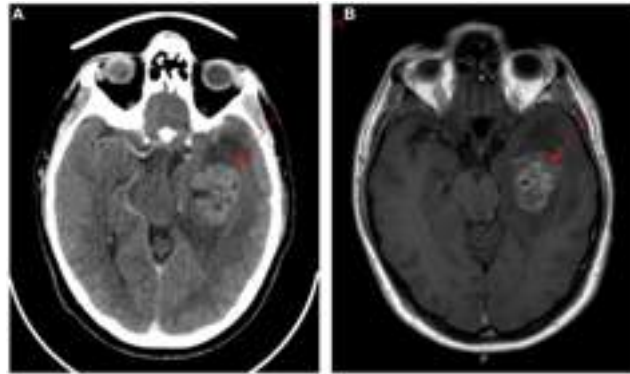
CT (A) and T1 weighted MRI (B) scans with contrast of a patient with GBM. Lesion indicated by red arrows.
